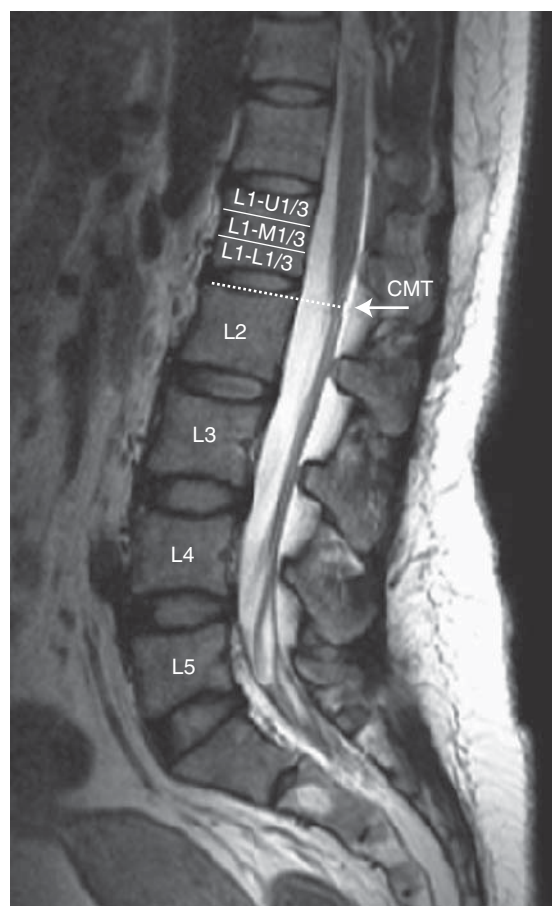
T2-weighted sagittal MRI of the lumbar spine, demonstrating the method used of dividing the vertebral bodies into three equal parts for the purpose of classification. The CMT is indicated by the arrow; the dashed line corresponds to its assigned spinal level (in this case, the L1–L2 intervertebral disc).
